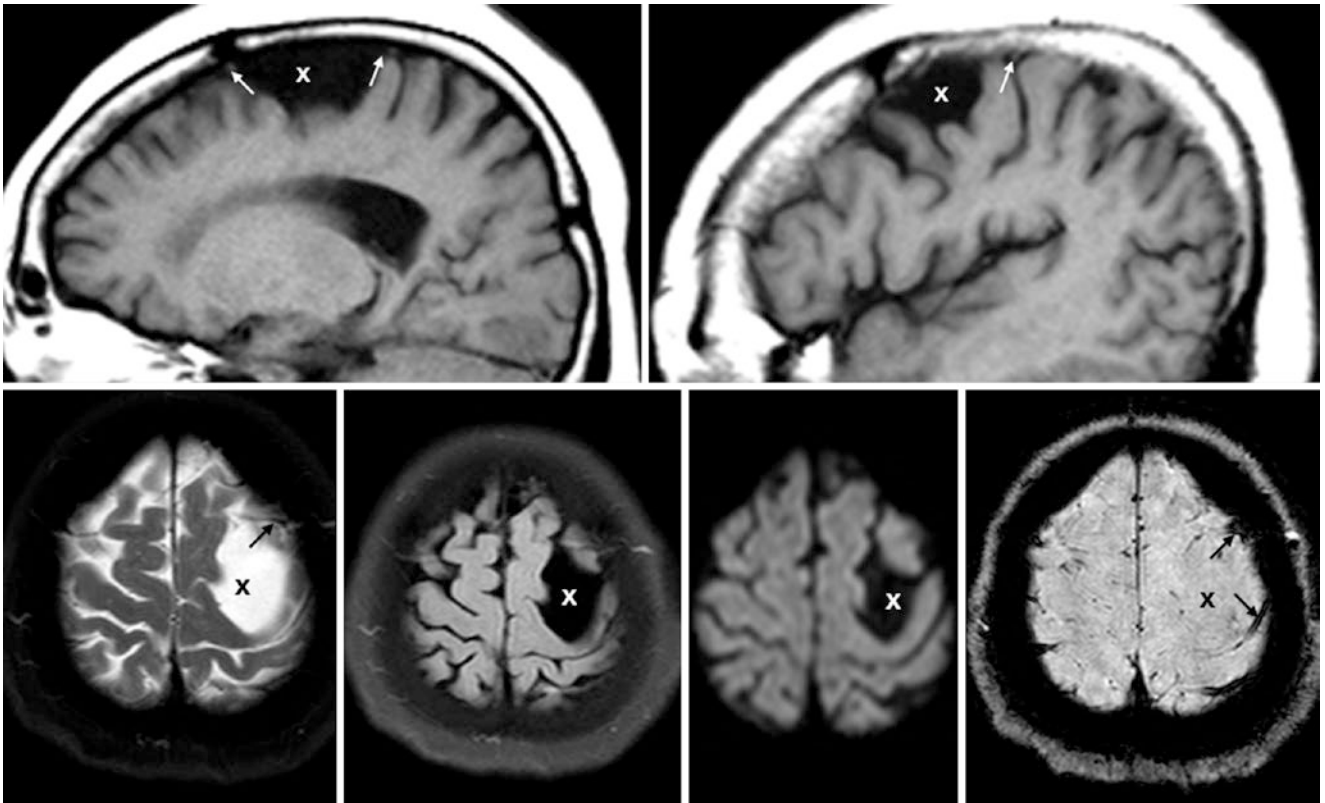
Comparison case of bilateral cerebral convexity ACs. In a 76 year old with headaches, sagittal T1WIs showed left- (*top left*) and right-sided (*top right*) ACs (x) displacing cortex and adjacent vascular structures (*thin arrows*). Axial T2WI (*bottom left*), FLAIR (*bottom left*
